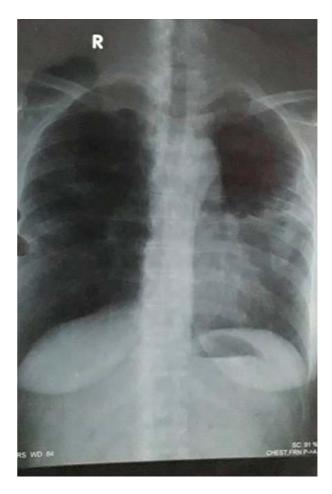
Chest X-ray (PA) – left lower lobe consolidation with bilateral hilar lymphadenopathy and left upper lobe cavitatory lesion.
